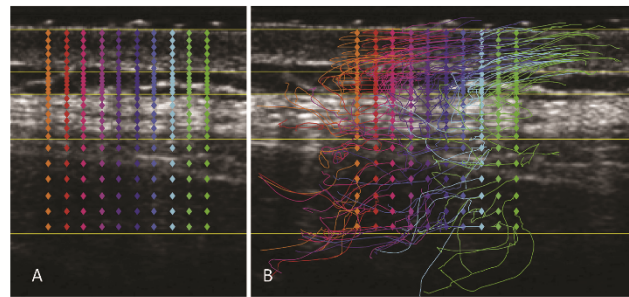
Demonstration of ultrasound tracking algorithm. A: an example of layer recognition with 60 points of interest. B: an example of results of 60 tissue movement routes during the lumbar flexion task.
